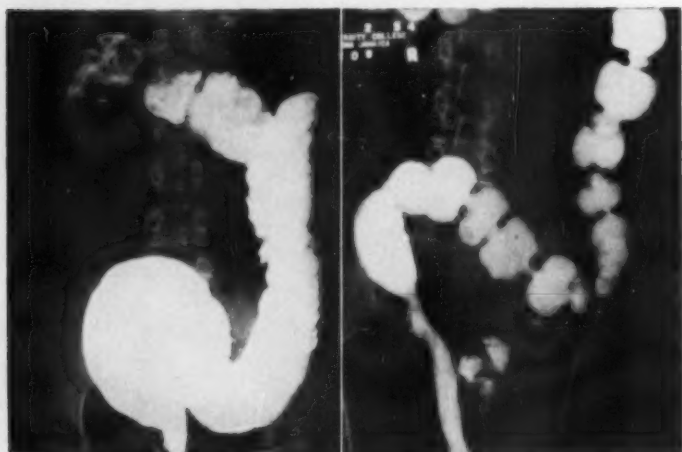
(left). X-ray showing tubular stricture of rectum with multiple pararectal sinuses and dilatation of colon.
